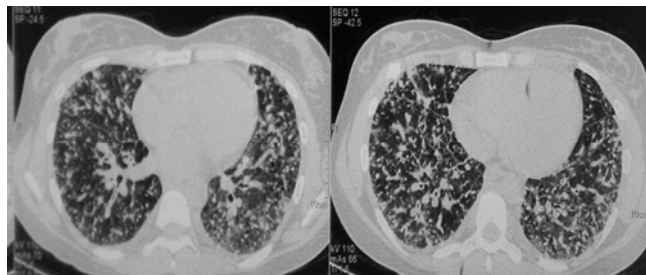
HRCT of lung on admission
